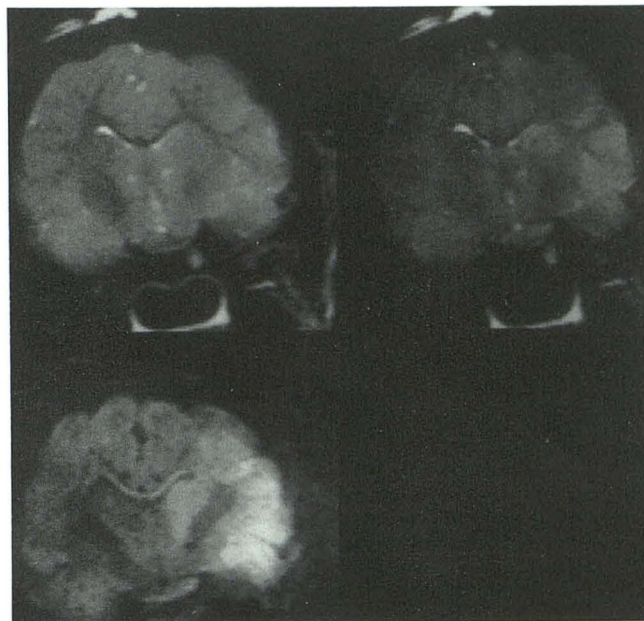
T2-weighted spin-echo images before (upper left) and after (upper right) administration of 0.5 mmol/kg Dy-DTPA-BMA approximately 1 hr after occlusion of right MCA. Corresponding diffusion-weighted image is shown at lower left. On the diffusion-weighted MR image, relative signal intensity ratios increased in the gray matter by 159% in the ectosylvian gyrus, 94% in the middle temporal gyrus, and 100% in the caudate nucleus. Corresponding signal intensity ratios increased in the magnetic susceptibility-enhanced MR image by 74%, 39%, and 101%, respectively. By comparison, the T2-weighted MR image without contrast did not clearly demonstrate the region of tissue injury at this early time.
